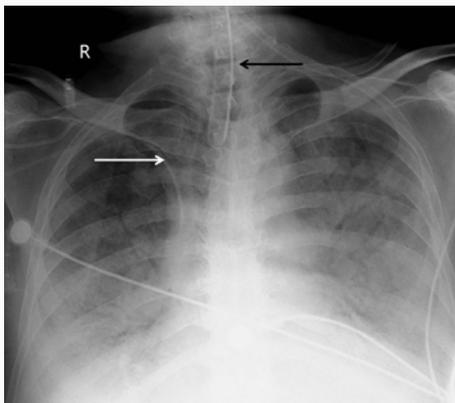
AP chest radiograph of 67-year-old female showing diffuse consolidation with air-bronchogram effect involving bilateral lung fields. Note the presence of endotracheal tube (black arrow) and CVP line (white arrow) *in situ*.
